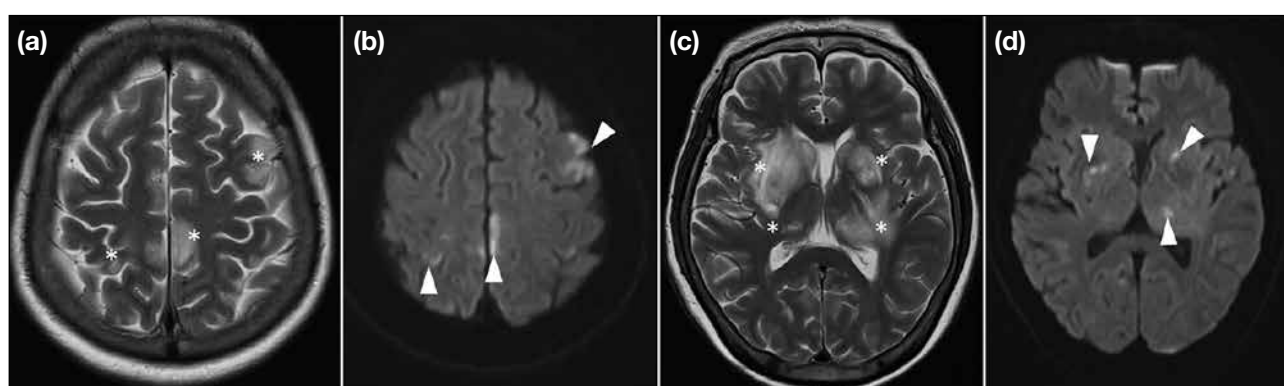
A 69-year-old woman presented with fever and confusion 3 days after dental surgery. (a) Axial T2-weighted magnetic resonance imaging (MRI) shows multiple foci of hyperintense signals involving the bilateral high frontal and parietal cortices (asterisks). (b) Axial diffusion-weighted imaging (DWI) with a high b-value revealed corresponding hyperintense signal (arrowheads) with low signal on apparent diffusion coefficient map (ADC) [not shown], suggestive of restricted diffusion. (c) Axial T2-weighted MRI shows hyperintense signals involving the bilateral basal ganglia, capsular regions, and thalami (asterisks). (d) Axial DWI with a high b-value shows patchy areas of hyperintense signal (arrowheads), with low signal on the ADC map (not shown), suggestive of restricted diffusion. These findings were suggestive of acute infarcts. The distribution pattern raised suspicion for an embolic shower, involving both deep perforating arteries and cortical branches. Consequently, an echocardiogram was performed and revealed a ventricular septal defect and tricuspid valve vegetation, consistent with a paradoxical embolism. The patient was managed conservatively with intravenous antibiotics and showed good neurological recovery.
